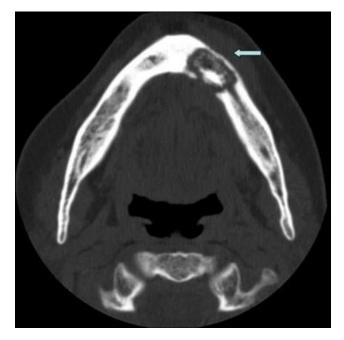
Axil CT image reveals sequestra (arrow).
